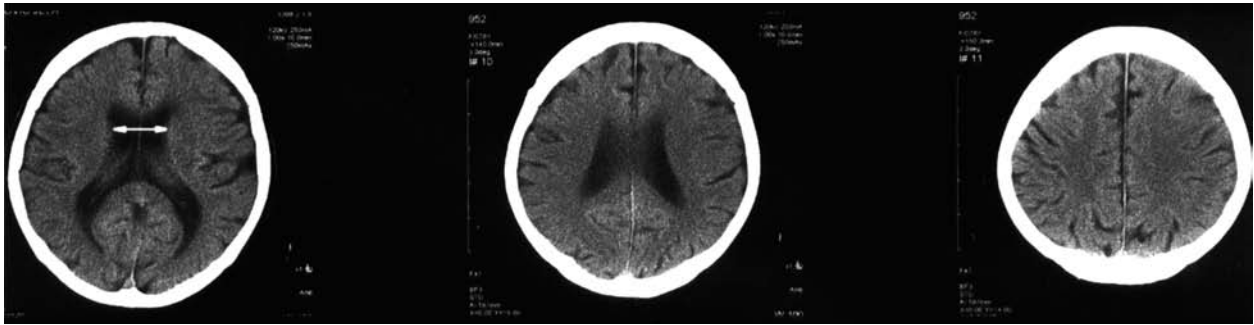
Second follow up CT scan shows complete resolution of subdural collection with well visualized subarachnoid space and symmetric position of the brain lobes (double-headed white arrow).
